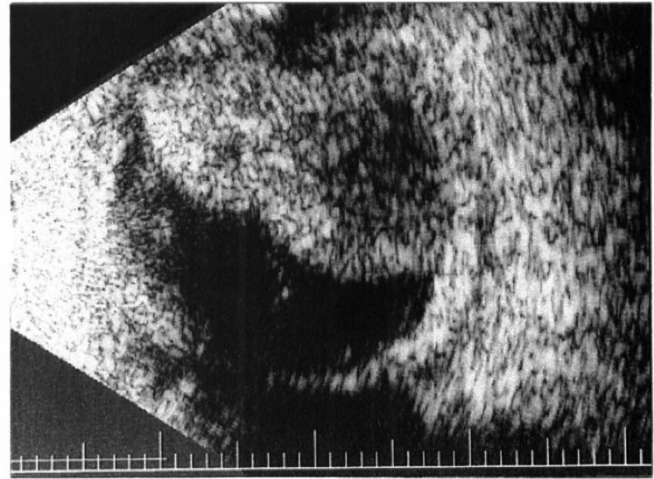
B-mode ultrasound scan (vertical section) showing a large superior choroidal detachment filled with a substance most likely to be blood. Also shown is a thickened posterior sclera with fluid in Tenon's space; this inflammation may be in part post-operative and in part secondary to infection.
